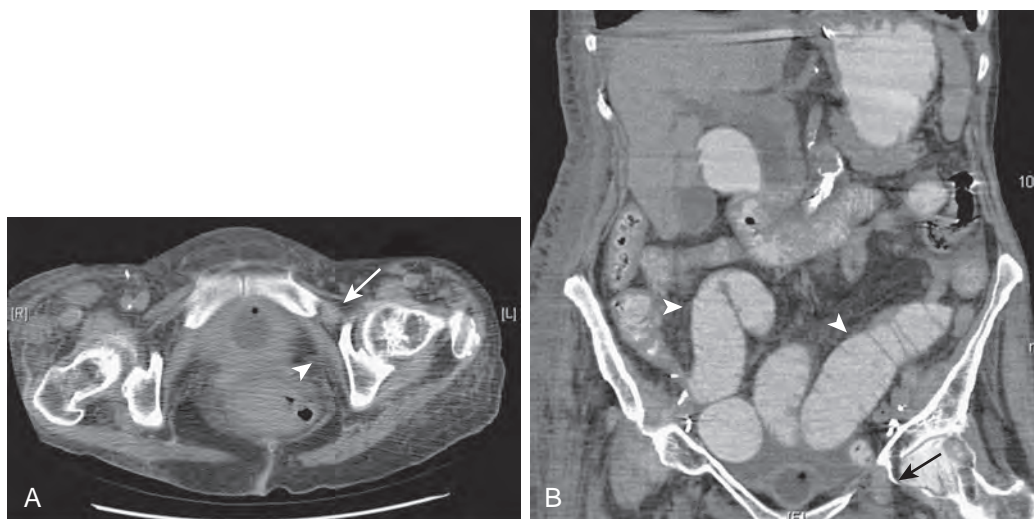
Obturator hernia causing small bowel obstruction. A. Axial CT of the pelvis in an older woman shows a left obturator hernia (arrow). Also note the left obturator internus muscle (arrowhead). B. Coronal CT of the pelvis shows the left obturator hernia (arrow), with dilated small bowel (arrowheads) proximal to the obstructing hernia.
